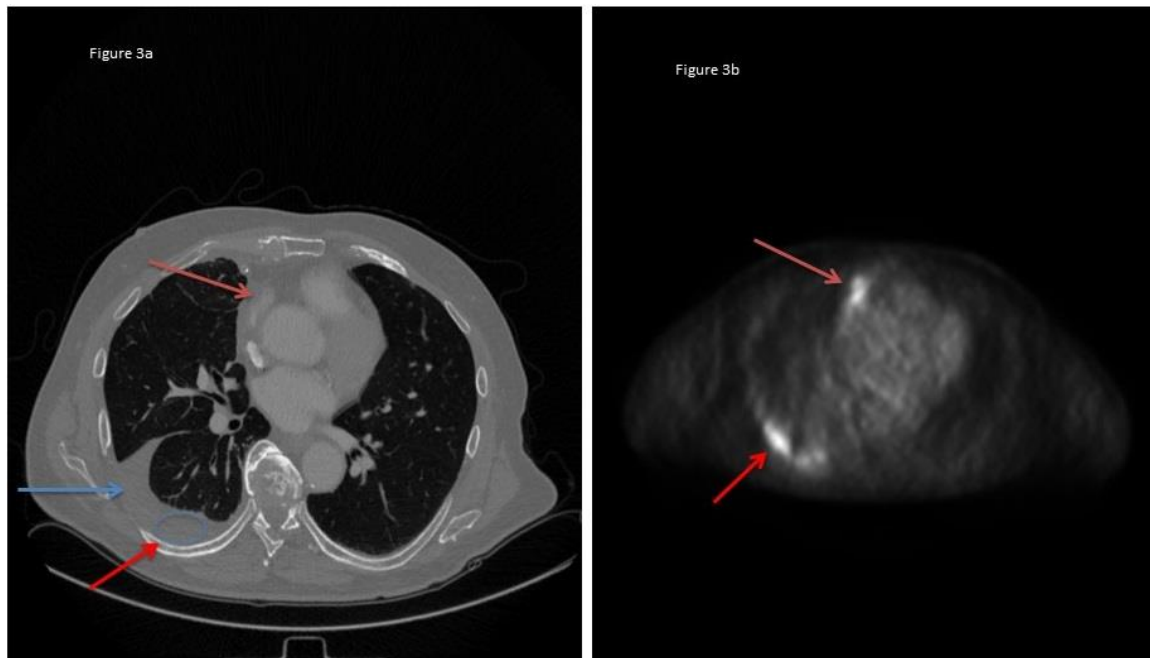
3a: Enhanced CT scan shows right hemithorax subpleural tumor (red arrow) associated pleural effusion (blue arrow) and enlarged right hilar lymph nodes. (orange arrow). 3b: PET image shows areas of enhanced 18 F-FDG uptakes corresponding to the right subpleural mass and effusion (red arrow) and right hilar lymphadenopathy (orange arrow).
